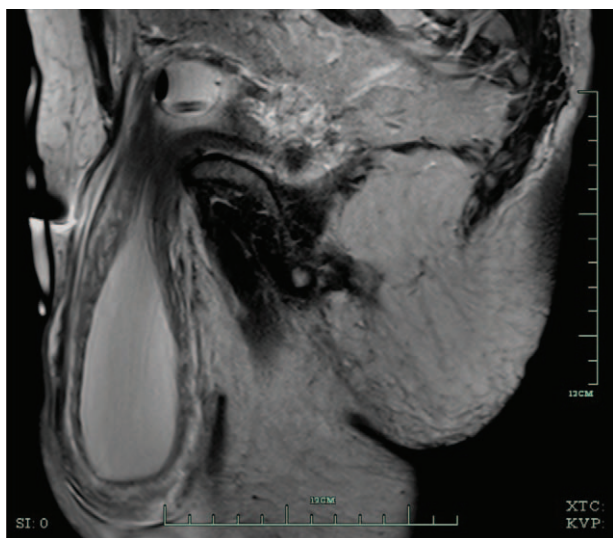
Magnetic resonance imaging (MRI) of the left-sided inguino-scrotal bladder hernia.
